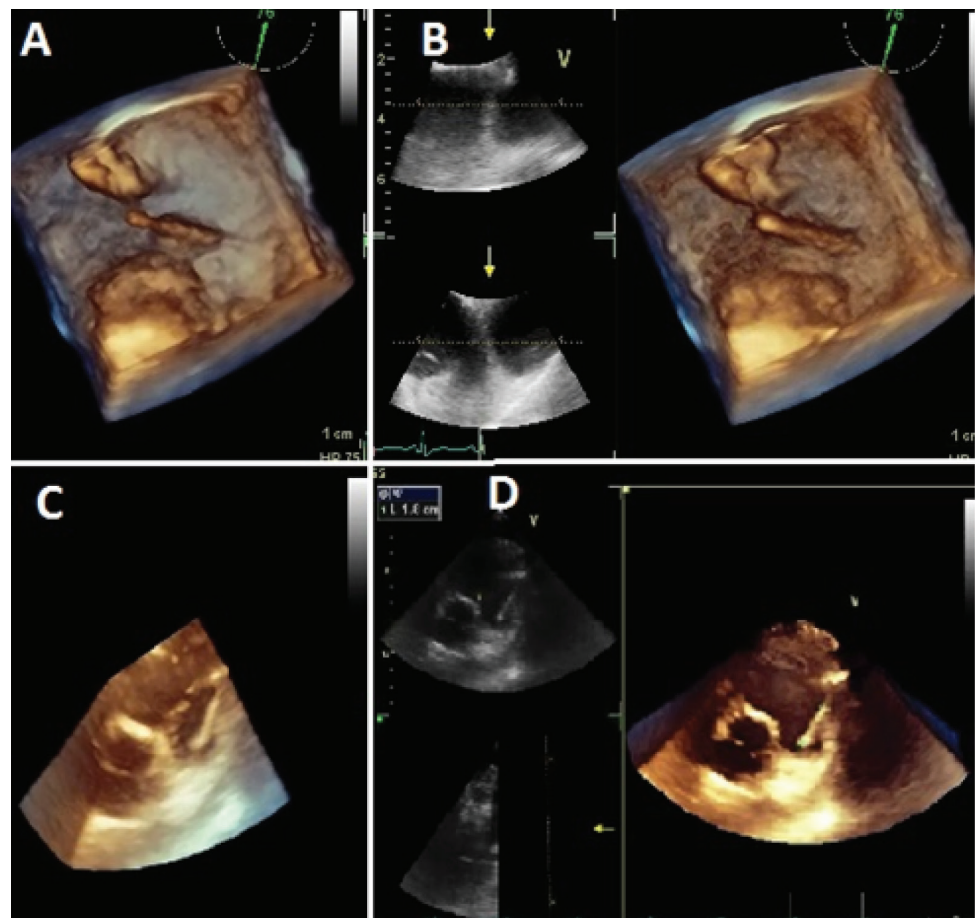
A, B 3D-Transoesophageal echocardiography of foreign body in right ventricular outflow tract. B, C 3D-Transthoracic echocardiography revealing foreign body in right outflow tract.
